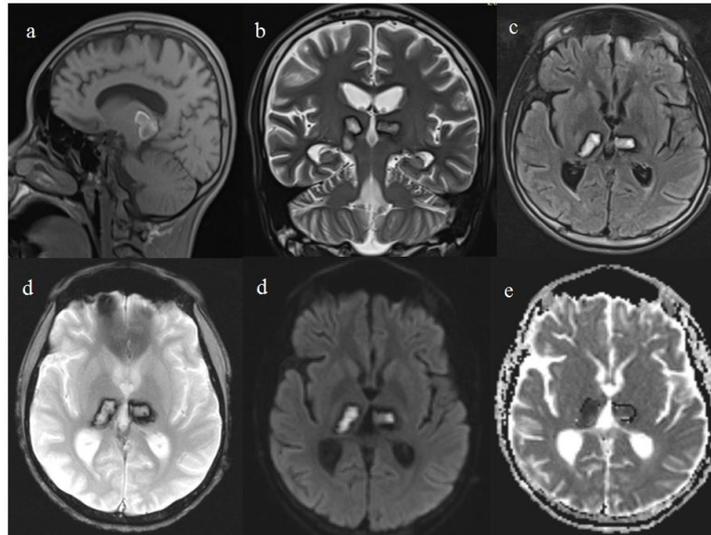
Morphological sequences of brain MRI.
